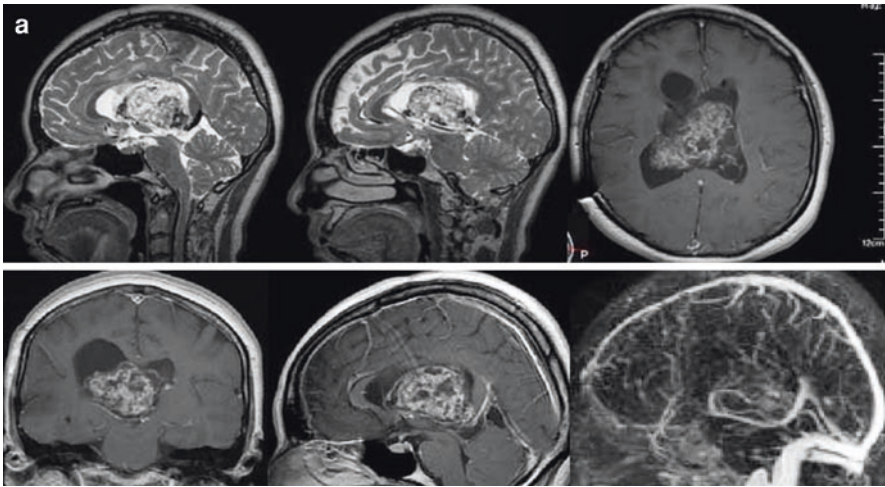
A 33-year-old man found that his ability to concentrate was becoming gradually impaired. He developed epilepsy and was transferred to another emergency hospital. There, a giant tumor was seen around the third ventricle. The patient was referred to our hospital for treatment. MRI obtained at consultation demonstrated a giant enhanced homogenous tumor ( $60 \times 65 \times 65$  mm) that involved bilateral A2A3 in the midpoint (a–c). The patient had no deficits and showed improved higher cognitive functioning after surgery. The pathological diagnosis revealed atypical meningioma (WHO grade I). The patient was discharged to his home after a short rehabilitation period and has since returned to work. Six months later, MRI showed no sign of regrowth (d–f). Skin incision, craniotomy, and meticulous dissection via AIH approach were performed. Although the surface of the tumor was soft and removable, the actual substance of the tumor core has very hard and strongly adhered to ACA midway between A2 and A3 portion bilaterally. We repeated coagulation and cutting of the feeders and meticulously dissected the tumor piecemeal. There were many small feeders all around the tumor. Eventually, we decided on a second-look operation in which the posterior part of the tumor was removed. A second surgery was performed 3 weeks later. First, we divided the anterior corpus callosum between the bilateral pericallosal arteries, visualized the tumor's posterosuperior part, and dissected the tumor in a piecemeal fashion (g, white arrowhead indicates the tumor and anterior corpus callosum.). The compressed fornix and anterior commissure were inspected (h, i). Finally, near-complete removal of the tumor was achieved using electrocoagulation for the residual part of the A2A3 adhesion (j)
